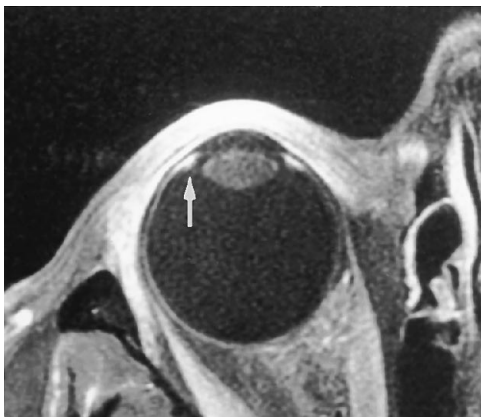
Ocular anatomy. Fat-suppressed T1-weighted (600/15) axial images after gadopentetate dimeglumine show the anatomy of the uveal tract, including the ciliary body (*arrow*) and the lens.
